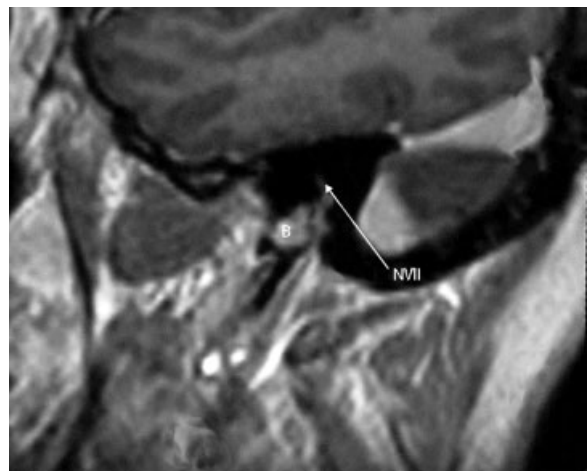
MRI T1 3-D contrast-enhanced, oblique reconstruction image: mastoid part of the facial nerve (N VII) in contact with the HJB (B).
